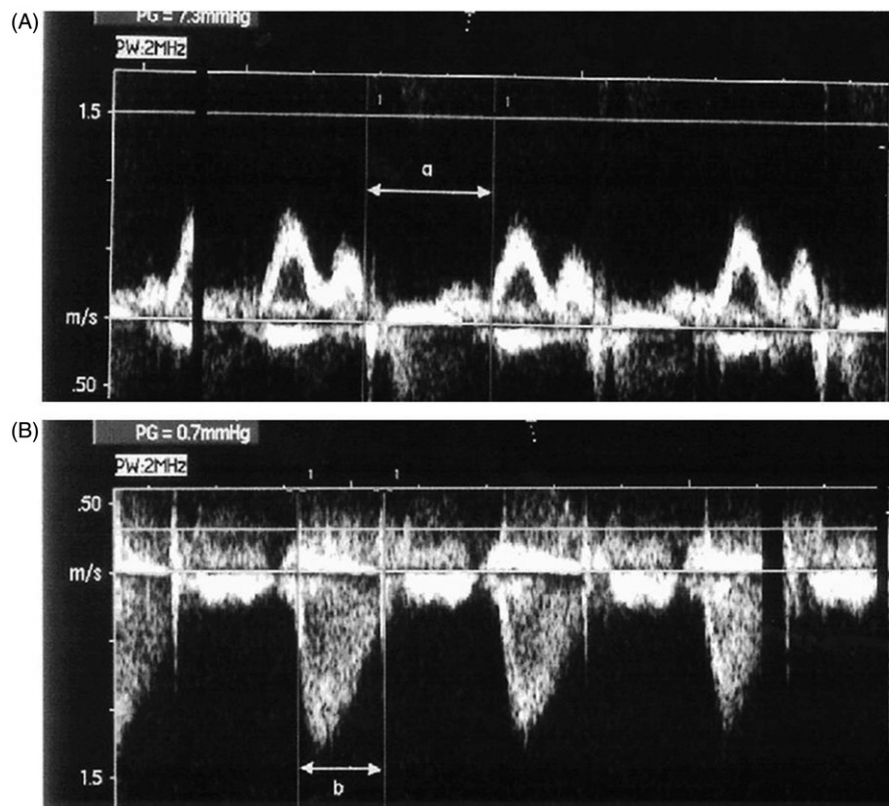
Measurement of time intervals used to calculate left ventricle myocardial performance index by PW Doppler method in different heart cycles: (A) total ventricular systole (a) and (B) left ventricle ejection time (b).
